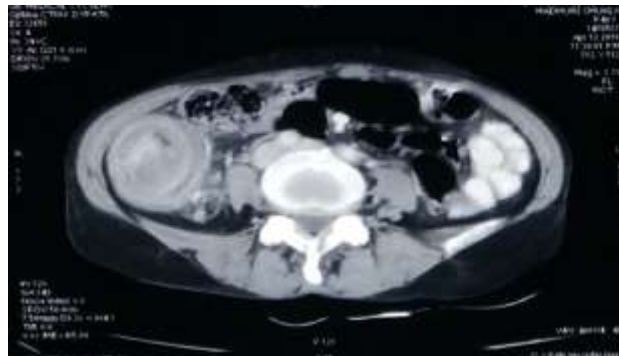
CT scan showing the typical target sign.
